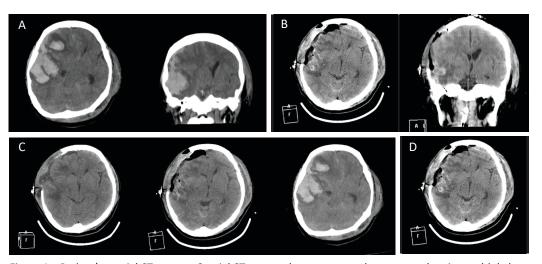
Patient's cranial CT scans. a Cranial CT scan at the emergency department showing multiple hemorrhagic contusions, a subdural haematoma and midline shift. b Cranial CT scan 24 h after the first surgery with decreased mass effect and bone defect. c Cranial CT scan 28 days after the first surgery compared with 24 h after the surgery and preoperatively. d Cranial CT scan 9 months after injury with cranioplasty showing minimal encephalomalacia
